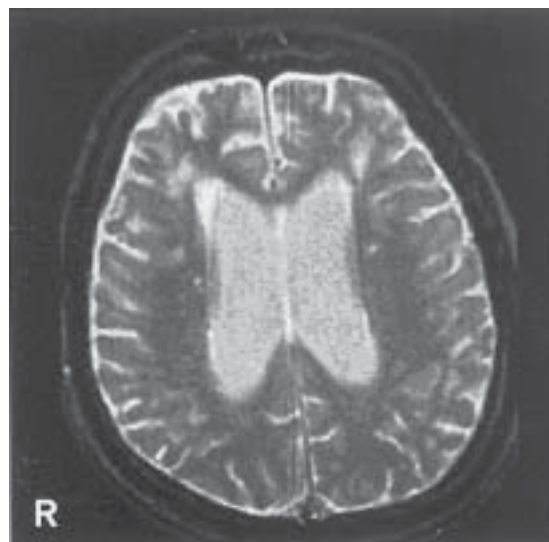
Brain magnetic resonance imaging (T2-weighted image) at the level of the lateral ventricle reveals mild, diffuse cerebral atrophy and dilation of the lateral ventricles. Small ischemic lesions are seen in both frontal lobes.
